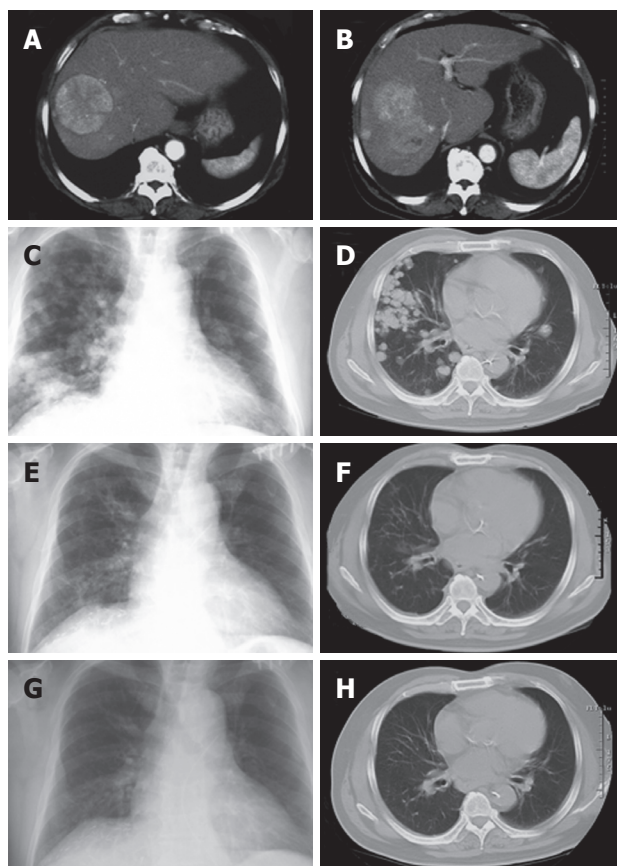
Chest X-ray and CT images before and after chemotherapy (A-H). Seven months before the chemotherapy, huge multiple HCCs were apparent in the right lobe of the liver (A, B). On admission before chemotherapy, multiple lung metastases were seen in the bilateral lung fields (C, D). Two months after starting chemotherapy, the multiple lung metastases had disappeared completely (E, F). Five months after starting chemotherapy, the tumors had not recurred (G, H).
